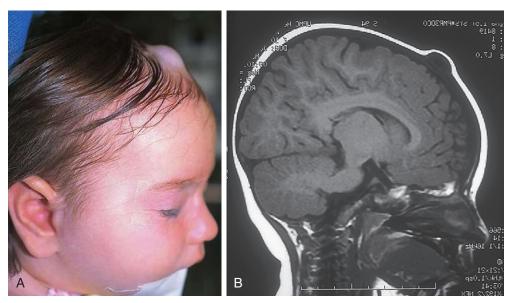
A, Midline scalp dermoid cysts may have intracranial extension and should always be evaluated by MRI before surgery. B, The dermoid in this 2-year-old child extends to but not through the dura.
